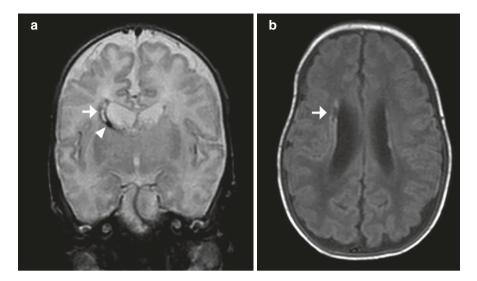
Grade IV subependymal hemorrhage in a preterm infant born at 26 weeks of gestation, scanned at the term equivalent age. Coronal T2-weighted image (a) shows very low signal dot (arrowhead) at the anterior horn of the right lateral ventricle, which is consistent with subependymal hemorrhage. The infarction (a: arrow) associated with the subependymal hemorrhage is demonstrated as a crescent-shaped high signal area abutting on the hemorrhage. On axial T1-weighted image (b), the infarction (arrow) is obtained as low signal intensity adjacent to the right lateral ventricle on a T1-weighted axial image
